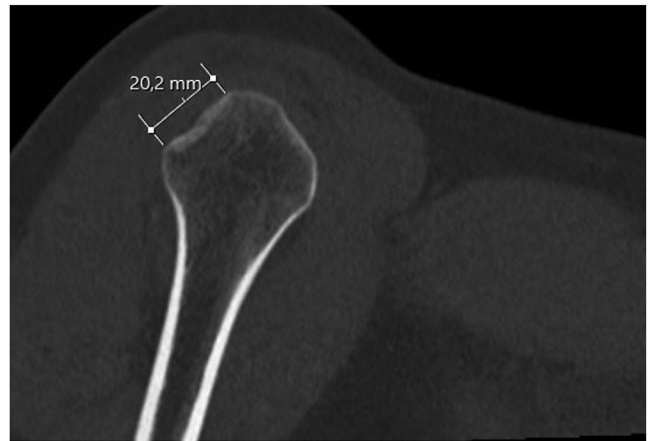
Three-dimensional reconstruction of a computed tomography scan in a patient lying on his back showing a right glenohumeral joint focusing on the Hill-Sachs lesion.
